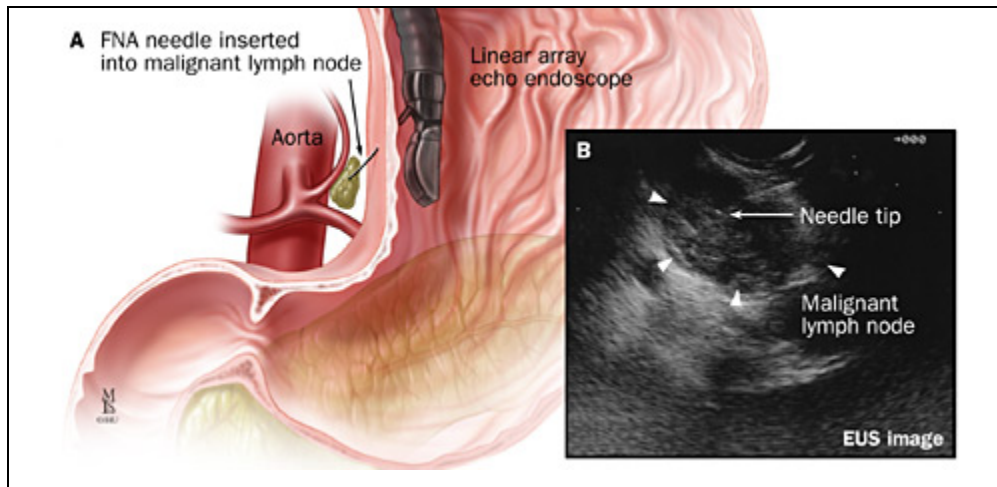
A, Technique of fine needle aspiration (FNA); B, corresponding endoscopic ultrasonography image. Source: Johns Hopkins Medical Institutions Digestive Disease Library
